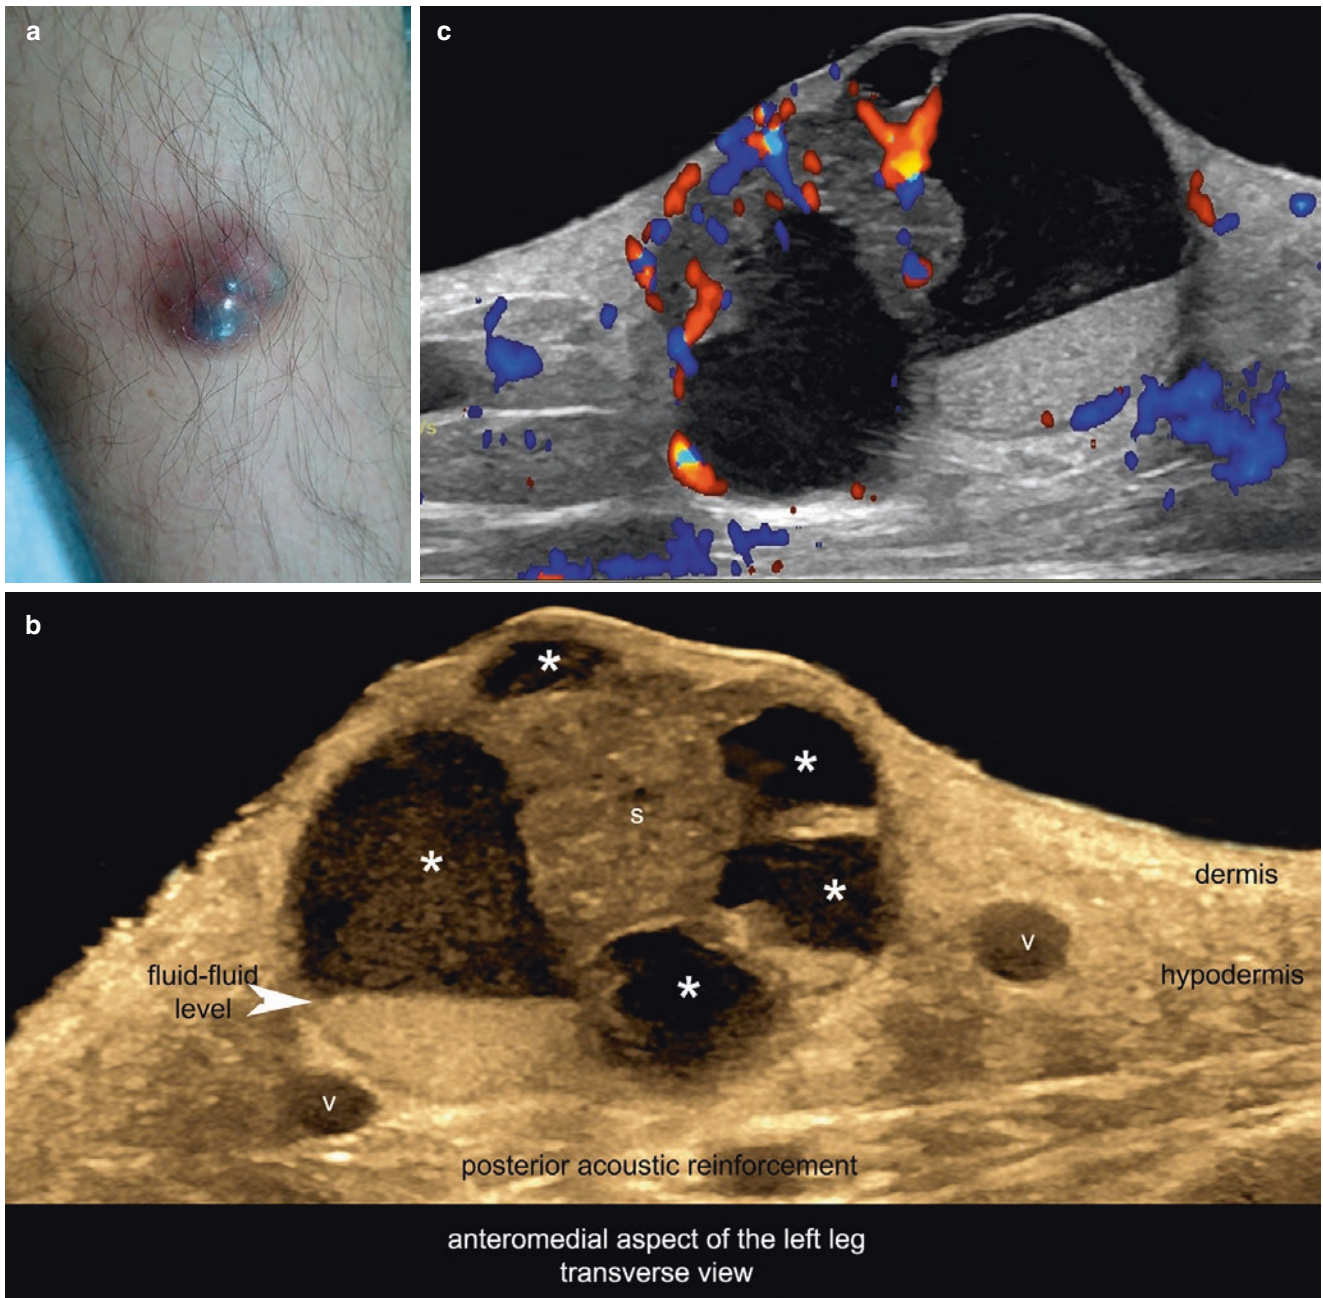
Apocrine hidradenoma. (a) Clinical image at the anteromedial aspect of the left leg. (b) Ultrasound (greyscale, transverse view) presents a well-defined, oval-shaped, dermal and hypodermal structure with hypoechoic
